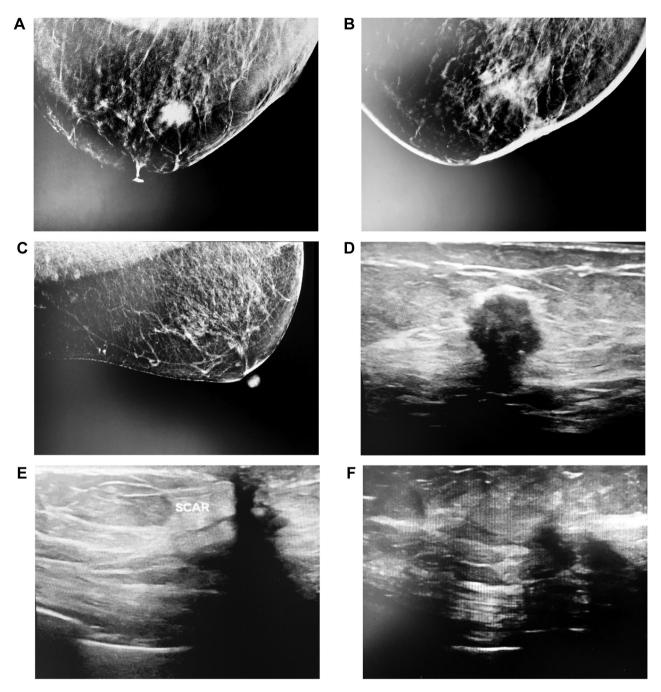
No recurrence of breast cancer was identified, after adjuvant therapy with DeltaRex-G, Trastuzumab and Letrozole in a patient with triple receptor positive invasive breast cancer. A, B, C: Mammogram at diagnosis, 6 months, and 1 year after treatment initiation; D, E, F: Ultrasound at diagnosis, 6 months and 1 year after treatment initiation.
